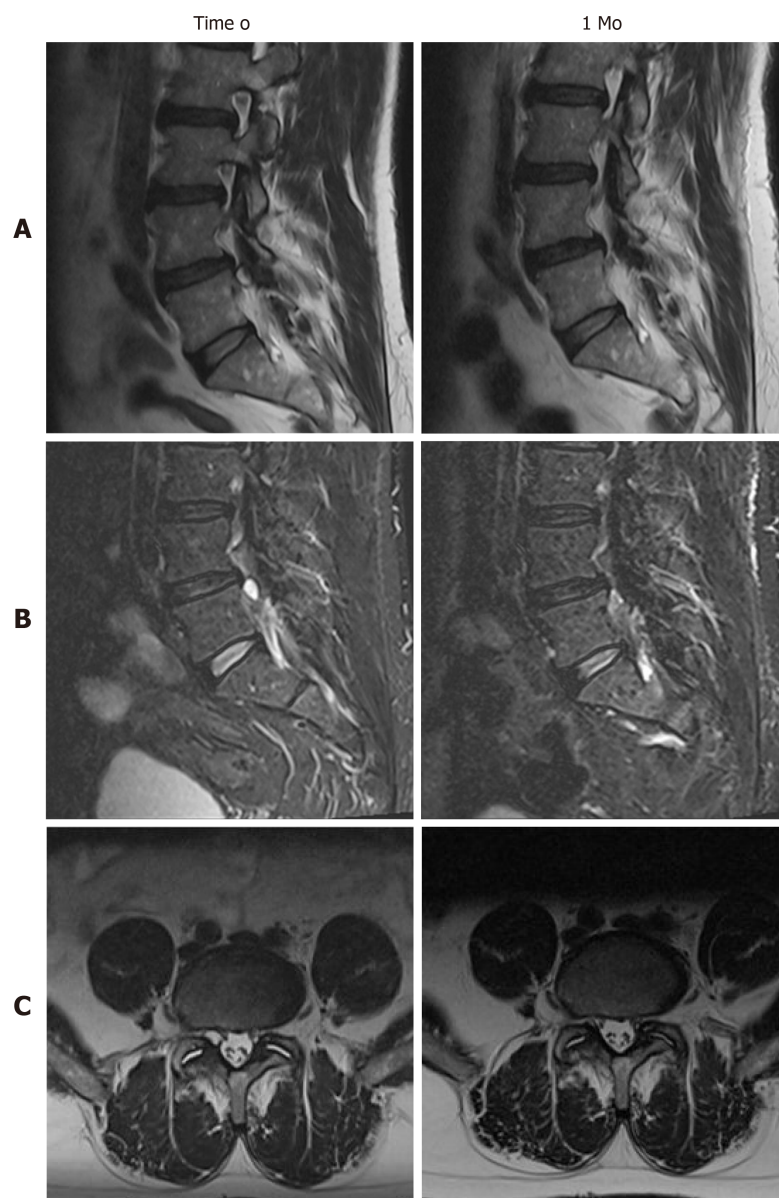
Radiological detection of the spontaneous disappearance of our right L4-L5 ganglion cyst, comparison of magnetic resonance imaging findings at observation (time 0) and follow-up (1 mo). A: Sagittal T2 images; B: Sagittal STIR T2 images; C: Axial T2 images: note the decrease of interfacet fluid amount at 1 mo follow-up.
